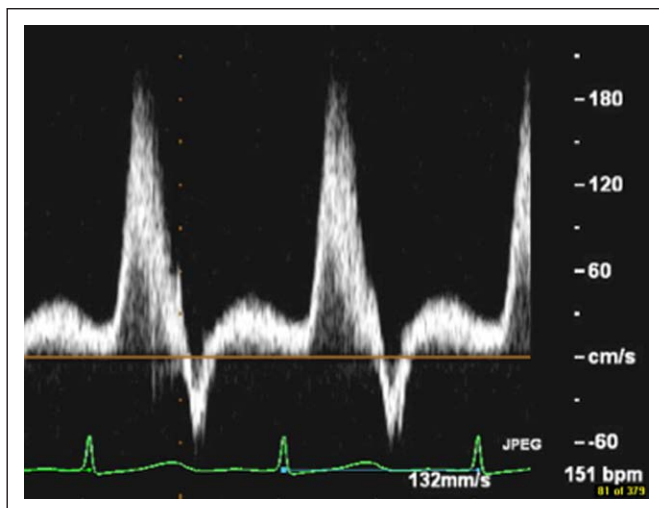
A still image of pulsed-wave Doppler of common carotid artery flow velocity, bpm = beats/min.
